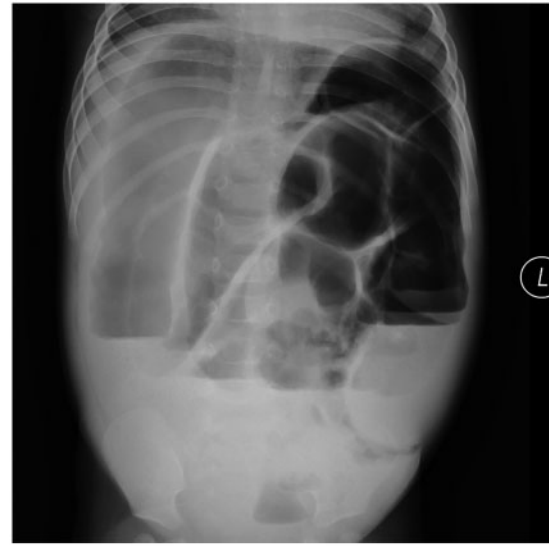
Abdominal X-ray showed proximal bowel dilatation
